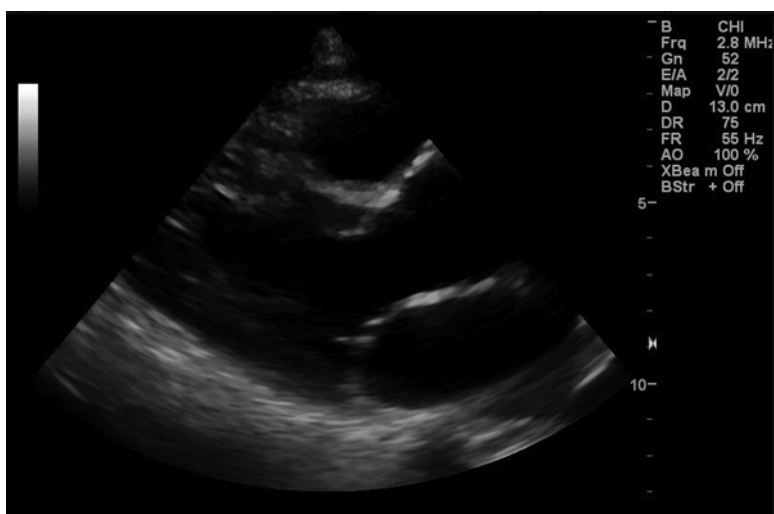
Showing the left parasternal long axis (PLAX) view of the heart with proper depth settings. The depth setting in this example is set at 13 cm
